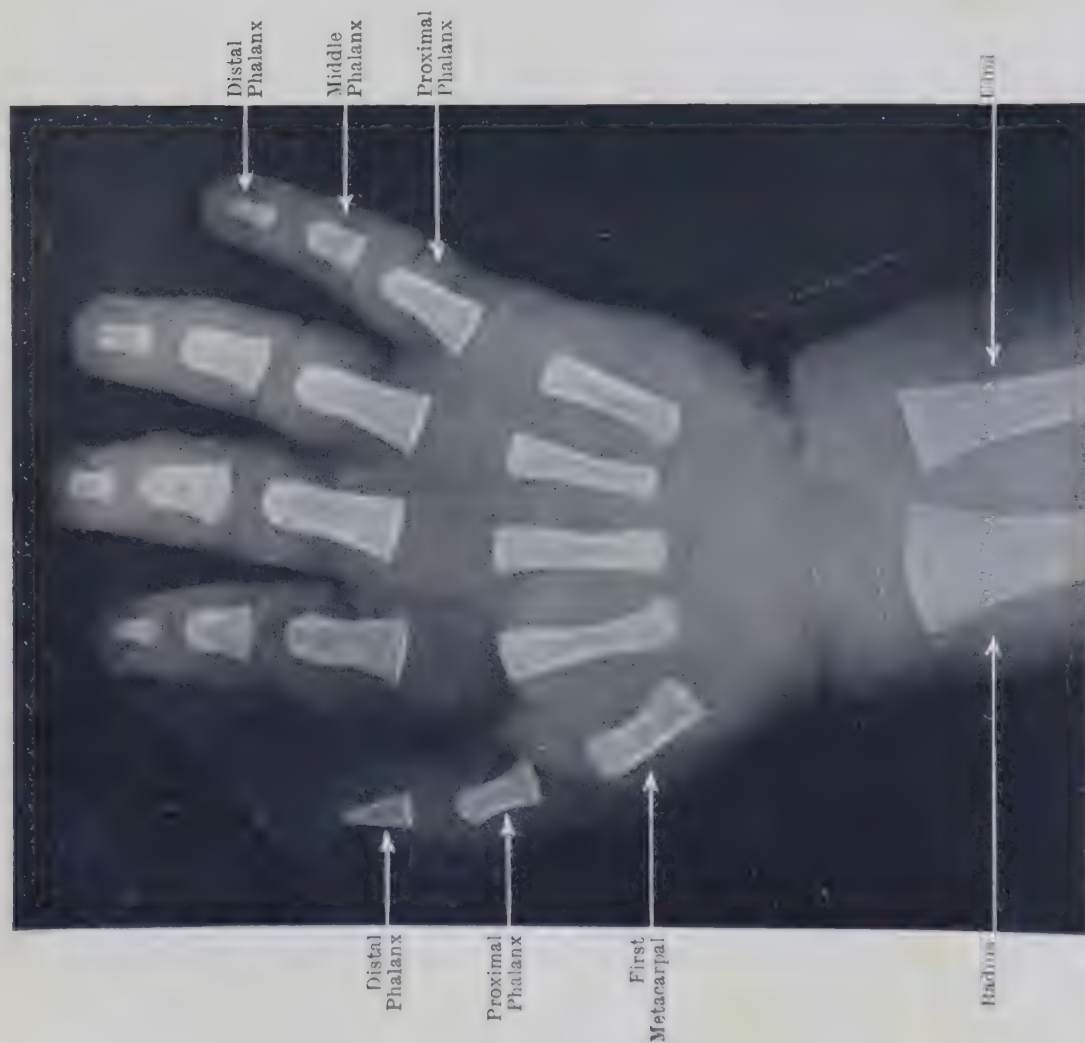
RADIOGRAPH OF WRIST AND HAND OF FULL-TIME FETUS.
